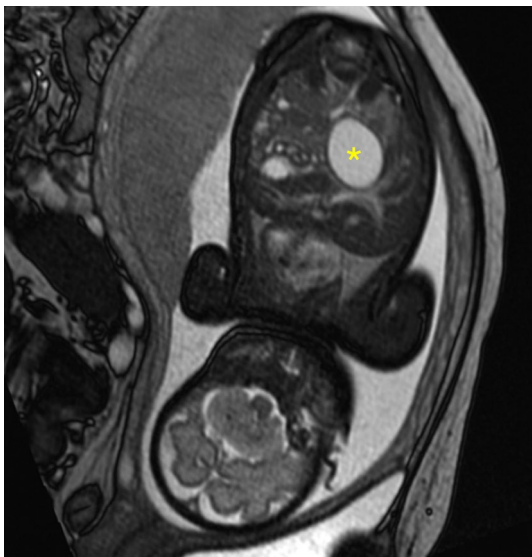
Prenatal magnetic resonance imaging suggestive of a choledochal cyst (*) requires differentiation from cystic biliary atresia if the cyst is not large
